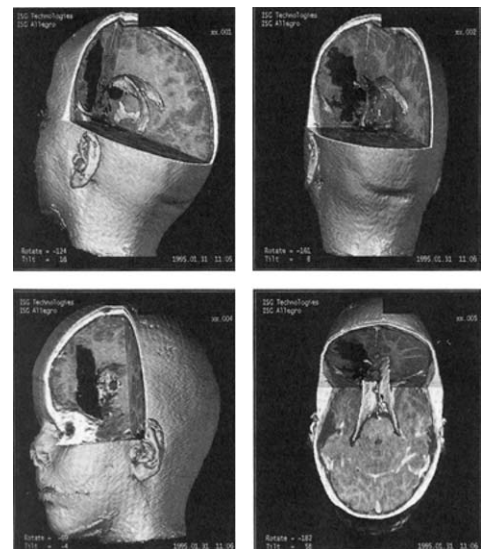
3-D reconstruction of SC2’s lesion from brain MRI. Reprinted from *Developmental Neuropsychology*, 19, Daigneault, S. et al., Pseudodepressive personality and mental inertia in a child with a focal left-frontal lesion, 1–22, 1997, with permission from Lawrence Erlbaum Associates, Inc.
